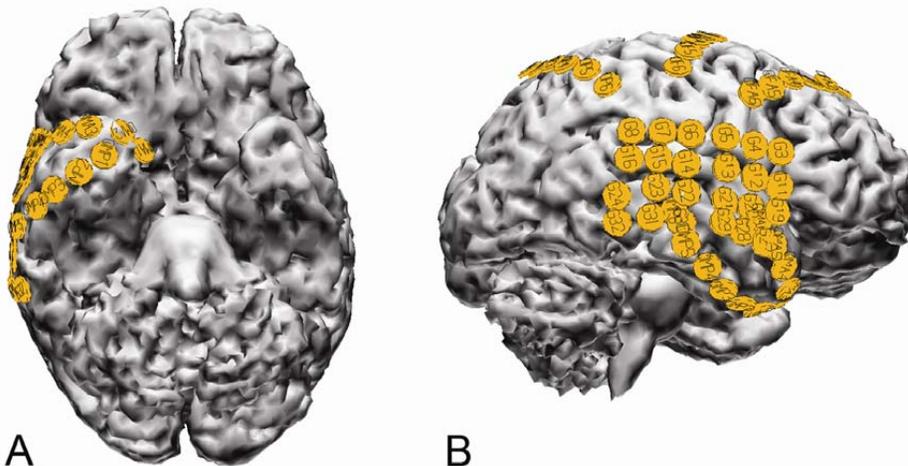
3-D reconstructed MR images of the subdural grid and five strip electrodes. The patient had a low grade tumour in the right middle temporal gyrus and a history
